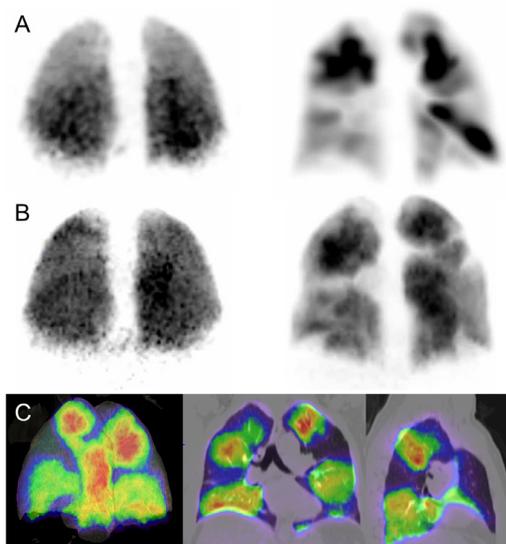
V/Q SPECT/CT compared to PET/CT in the same patient with diagnosis of acute pulmonary embolism. (A) Maximum intensity projection (MIP) ventilation (left) and perfusion (right) SPECT demonstrates normal ventilation with multiple large unmatched perfusion defects consistent with acute pulmonary embolism. (B) MIP PET findings mirror the SPECT/CT findings. The unmatched defects are more clearly defined on PET with sharper cutoff. (C) Perfusion PET fused with volume rendered lung CT (left), coronal (middle), and sagittal (right) PET/CT clearly demonstrates large segmental perfusion defects.
